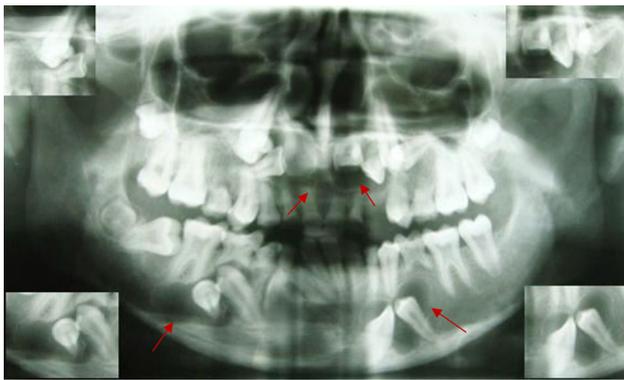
Panoramic radiograph is showing bilateral radiolucencies in maxilla and mandible
